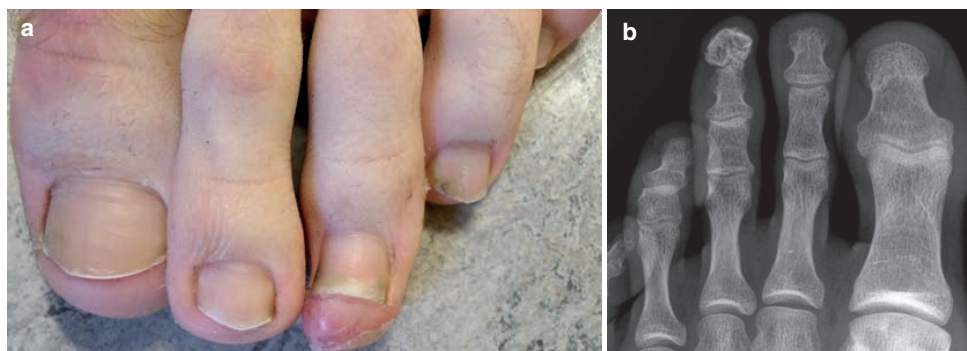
(a) Enchondroma distal phalanx 3rd toe. (b) Radiographic appearance
